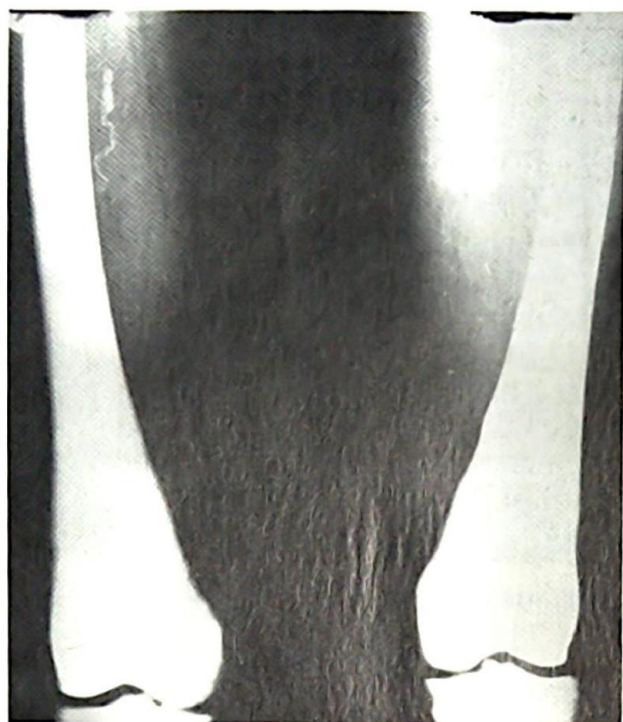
X-ray of patient's femora — showing generalized sclerosis and a pathological fracture of the proximal shaft on the left side.
